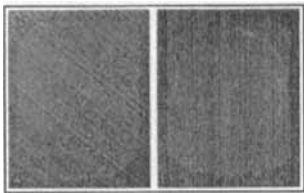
X-ray of sample where A shows sample before testing. B shows sample after 1x10⁶ cycles.
